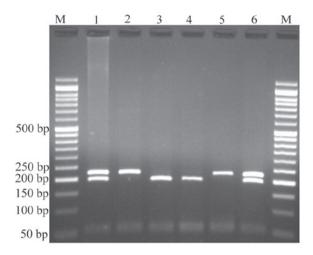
Electrophoresis of rs4848320 C>T polymorphism fragments. The C allele was digested by *Pst*I and produced a 195 bp fragment and presumed 27 bp fragment not visible on agarose gel, while the T allele remained undigested (222 bp). M: DNA marker; lanes 1 and 6: CT; lanes 2 and 5: TT; lanes 3 and 4: CC.
